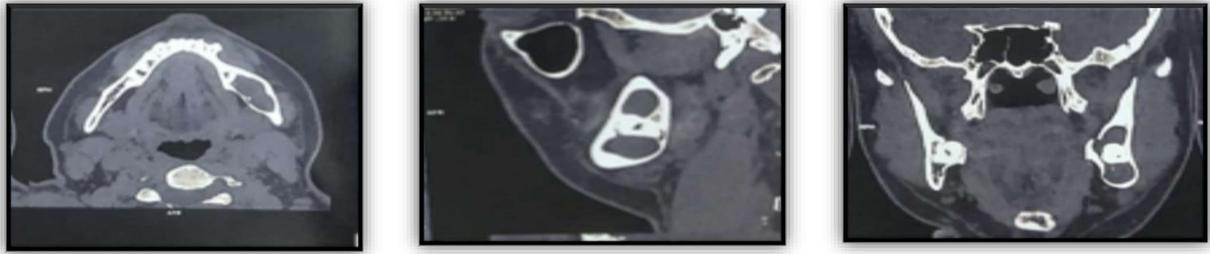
CT of left mandible showing various sections (a) Axial (b) Sagittal (c) Coronal
